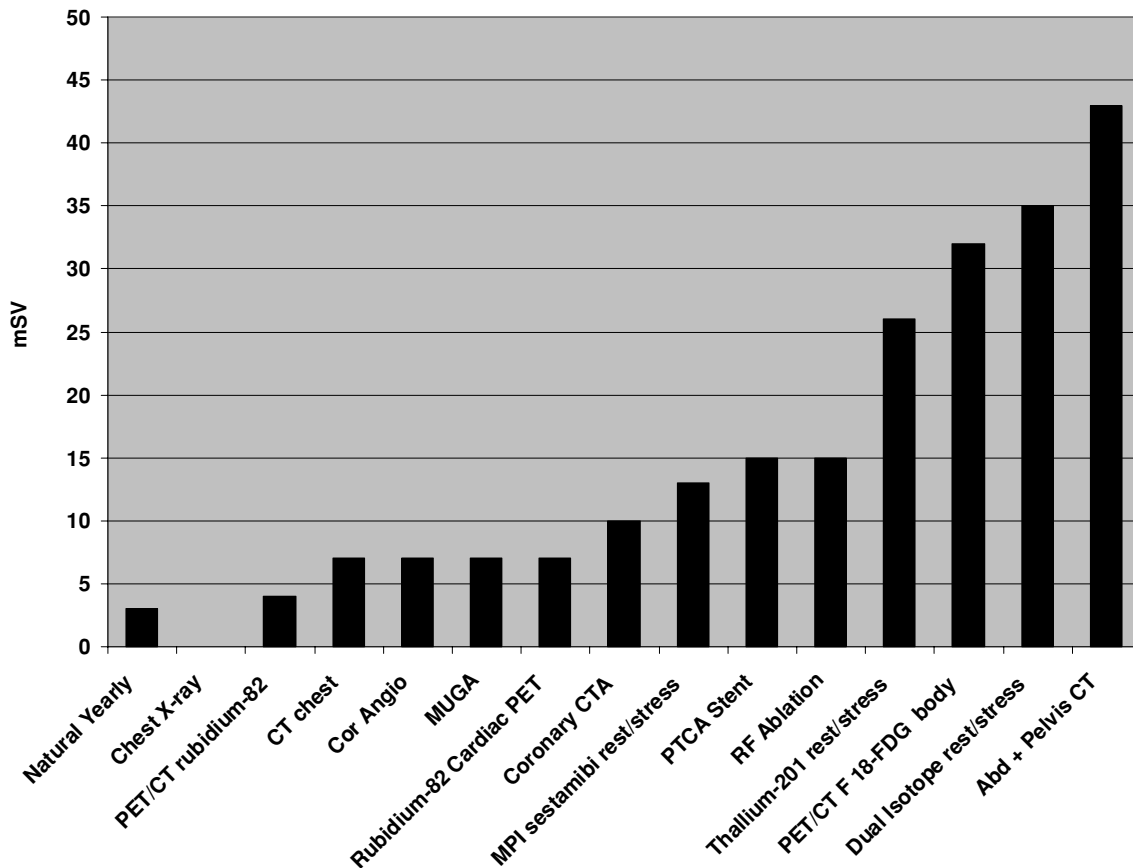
Radiation Exposure. Estimated radiation exposure (mSv) in the natural environment (Natural Yearly) and for various radiological procedures. Each radiological procedure is subject to variation in radiation exposure, dependent on factors including the patient, operator, and manufacturer. (Cor Angio) – coronary arteriography, (PTCA Stent) – percutaneous transluminal coronary angioplasty and stent, (RF Ablation) – cardiac radiofrequency ablation, (Abd + Pelvis CT) – combined abdominal and pelvis CT, (MPI) – myocardial perfusion imaging, (PET) – positron emission tomography.
